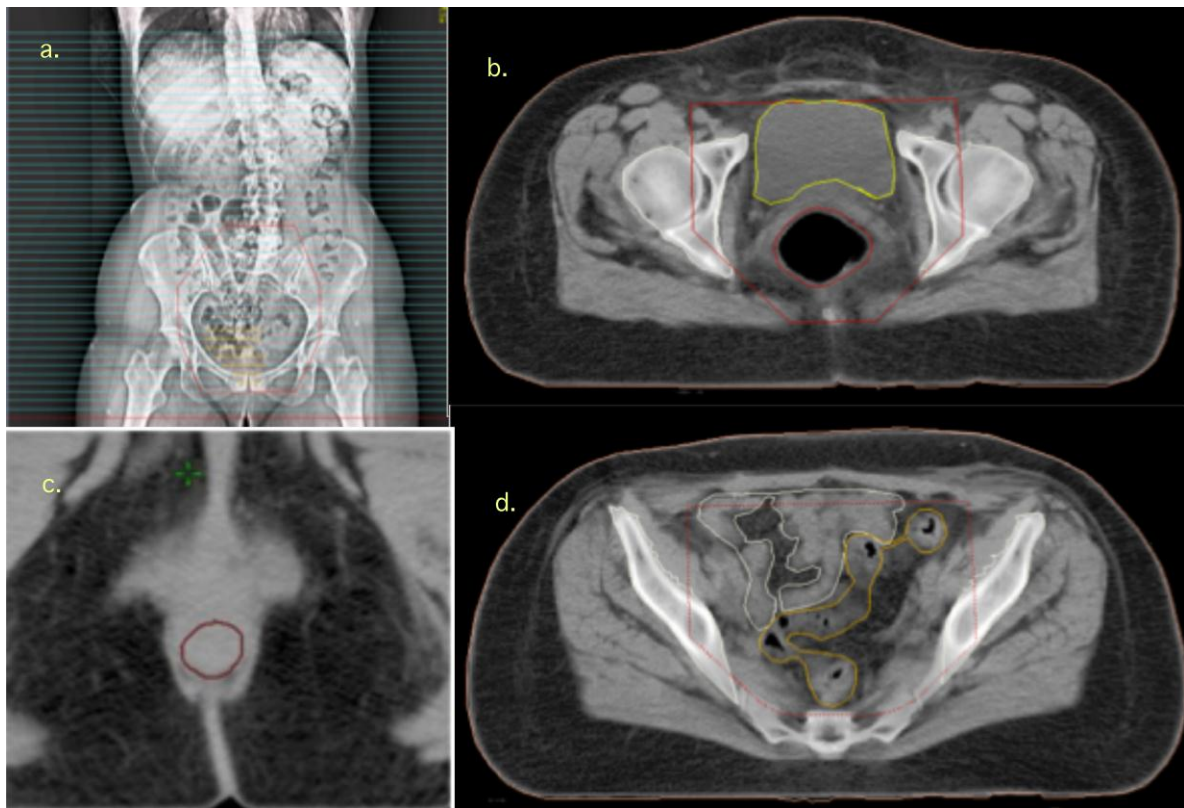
a. CT scan of a patient, showing the rectum outlined with yellow color contour, the pelvic field outlined with red contour. b. The PTV and the rectum are outlined with red contour and the urinary bladder with yellow. c. The anal-sphincter region outlined with red contour. d. The sigmoid outlined with orange contour and the small intestines with white.
